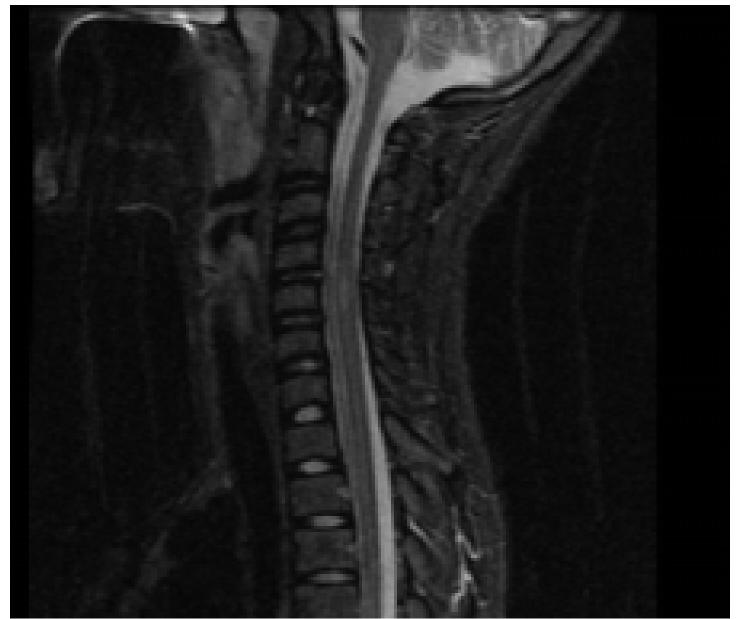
MRI of cervical spine, sagittal STIR sequence, from hospital readmission, showing small focus of nonenhancing signal abnormality in the cord at the C5 level. Findings were consistent with demyelinating process.
